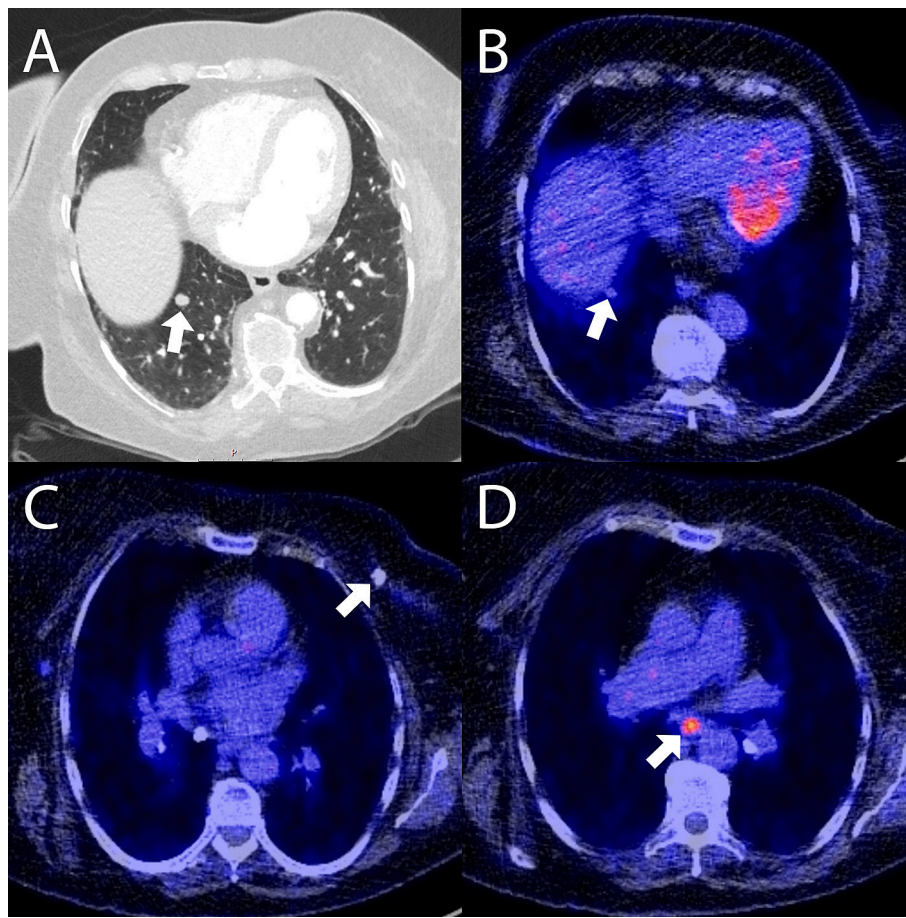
A 76-year-old female in whom cardiac CT was performed to assess for coronary atherosclerosis prior to pulmonary vein isolation, with an incidentally discovered 10x9x8 mm pulmonary lesion (A, arrow). This pulmonary lesion turned out to be metabolically inactive on FDG-PET/CT (B, arrow). However, FDG-PET/CT showed a calcified lesion in the left breast (C, arrow) and an FDG-avid mediastinal lymph node (D, arrow) as new incidental findings. Mammography of the left breast diagnosed a (benign) BI-RADS lesion. No further investigation was performed for the mediastinal lymph node.
